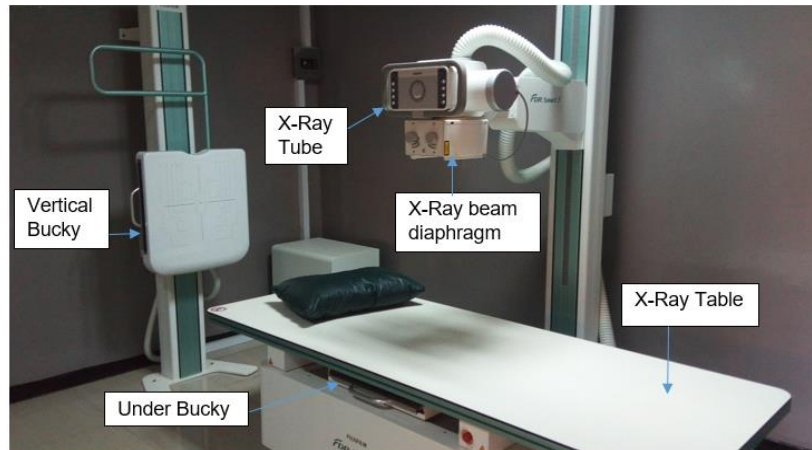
Image of the Fuji X-Ray unit
